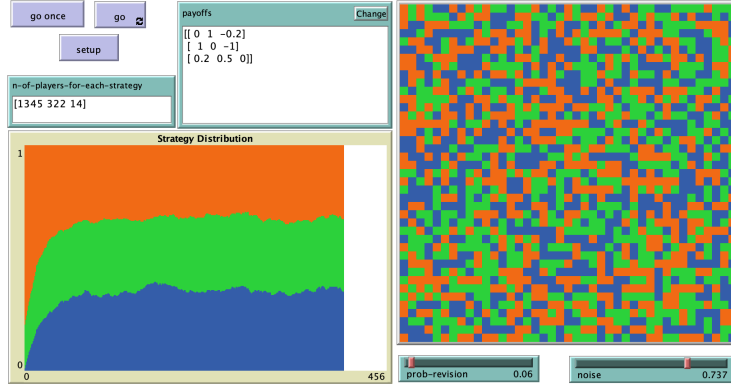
Small PA population benefits moderately from CT bacteria, with the presence of noise: $\alpha > \beta + 1$, $\alpha = 1$, $\beta = -0.2$
